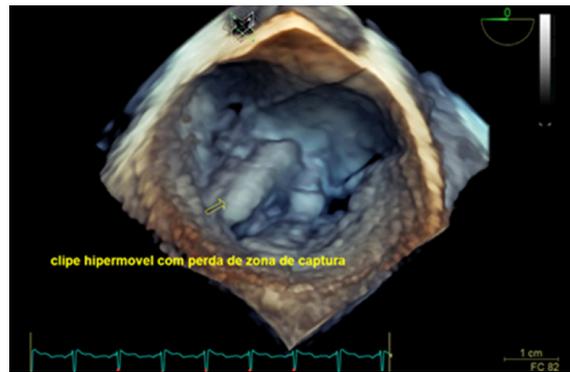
Three-dimensional transesophageal echocardiogram (3DTEE) with three-dimensional reconstruction showing MitraClip capture loss.
